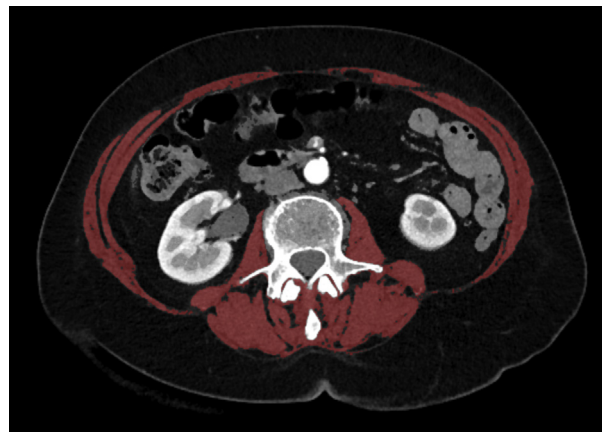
Example of skeletal muscle mass and density measurement on a contrast-enhanced CT slice in the portal-venous phase at the level of the third lumbar vertebra (L3). The cross-sectional skeletal muscle area of this 71-year-old woman with a body mass index of 24.7 kg/m² was 95.6 cm², resulting in a skeletal muscle index of 33.1 cm²/m². The mean skeletal muscle attenuation was 33 Hounsfield units. According to the cut-off values of Martin et al. [24], this patient is considered to have both sarcopenia and low skeletal muscle density.
